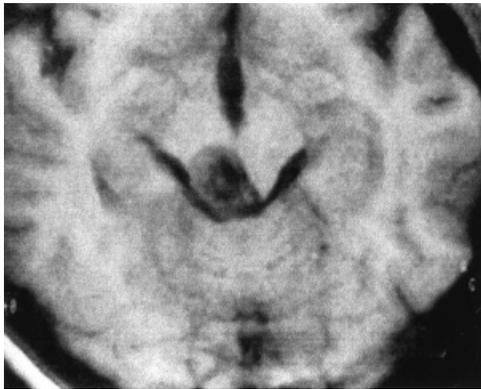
Axial T₁-weighted MRI of a patient with focal tectal brainstem glioma.
